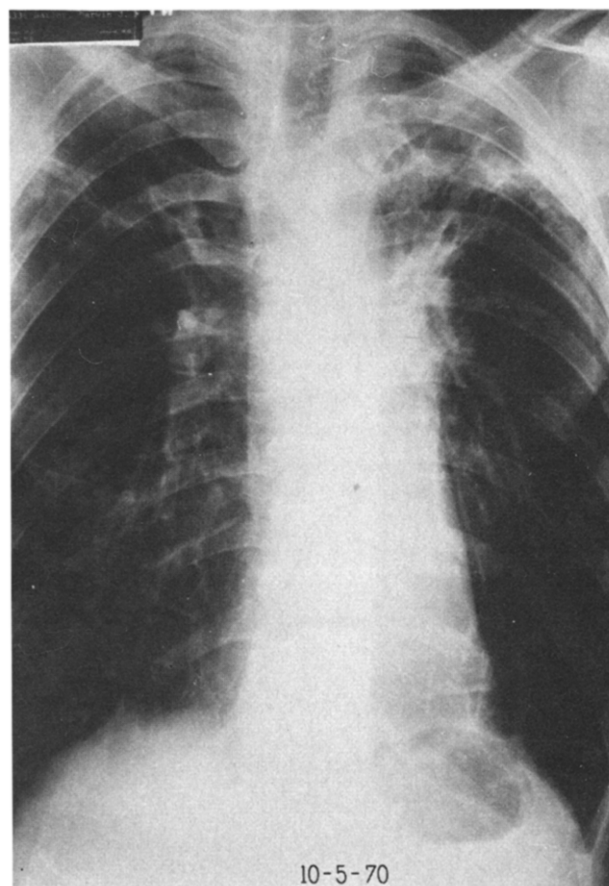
Case 2. Chest roentgenogram of October 15, 1970, showing clearing of infiltration.
